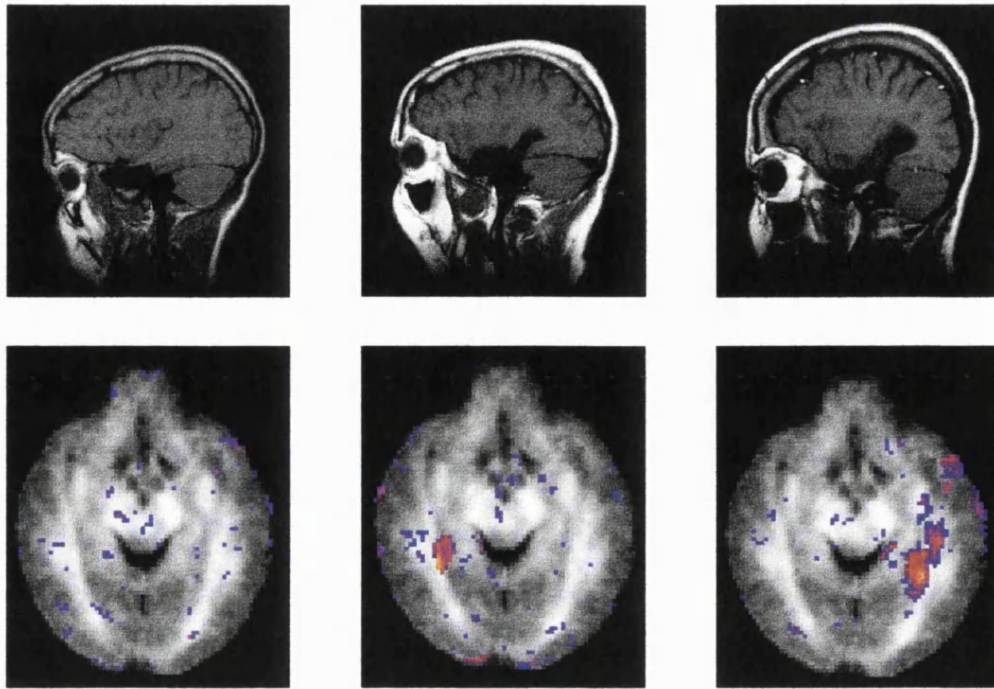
Top: Sagittal T1-weighted images. Bottom: Axial averaged maps of the fractional anisotropy of normal controls, showing myelinated pathways including the optic radiation overlaid with regions of significantly reduced anisotropy in the patients (scaled from blue = 2SD to yellow = 2SD-200). Left: patient 1, right amygdalo-cortectomy, no visual field defects. The optic radiation is normal. Middle: patient 2, right standard resection, clinically no visual field defect. Only the most medial fibres of the optic radiation are affected. Right: patient 3, left standard resection, clinically hemianopia to the right. Significant reductions of the anisotropy suggesting a breakdown of myelin are visible in the left optic radiation exceeding the resection line. (Note that patients left is right on axial images.)
